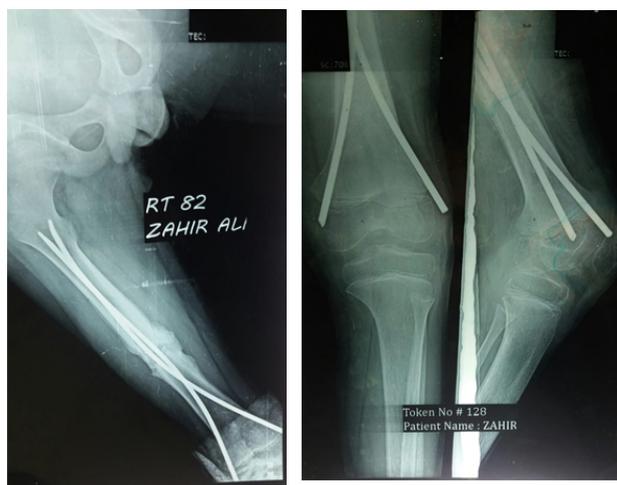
Postoperative radiograph after 6 weeks of surgery
